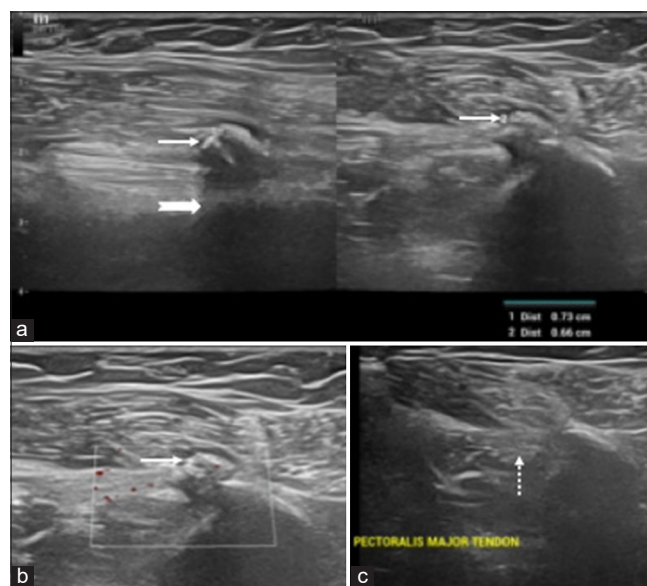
(a and b) Ultrasonographic images showing lobulated calcification (white arrows) with prominent posterior acoustic shadowing (notched white arrow) at the insertion of pectoralis major tendon into the humerus. There was mild increase in Doppler vascularity with biphasic low amplitude arterial flow. No frank hypervascularity seen. (c) The pectoralis major tendon otherwise appears intact (dashed white arrow).
